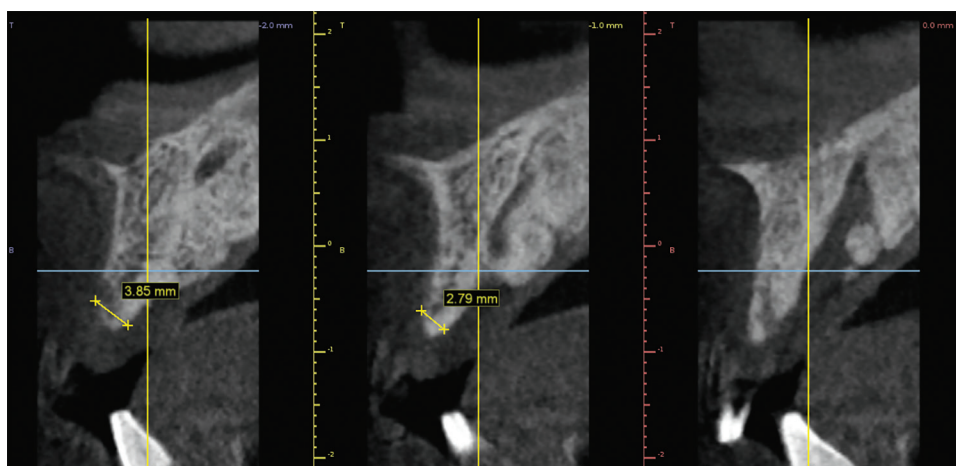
Radiological examination using CBCT
